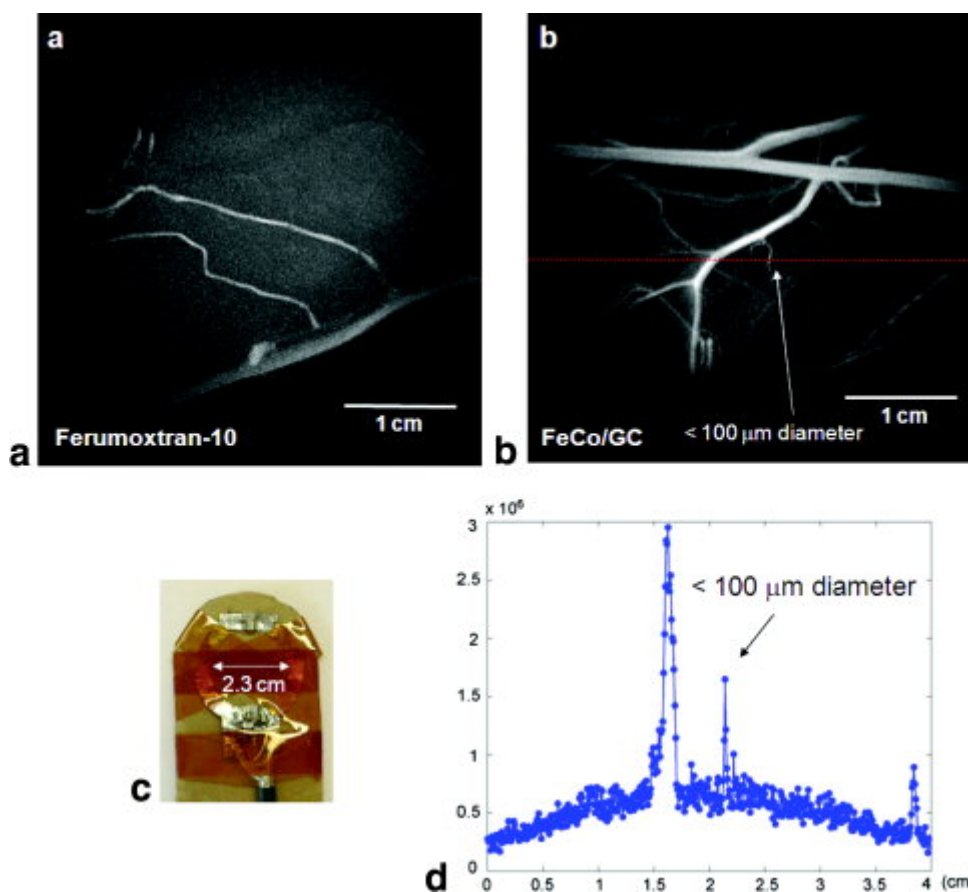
Reproduced from [98]. In vivo high-resolution MRI: (a) a vasculature MIP image enhanced by 1-mM blood pool concentration of ferumoxtran-10, (b) a vasculature MIP image enhanced by 0.2-mM blood pool concentration of FeCo/GC, (c) picture of 2.3 cm diameter
